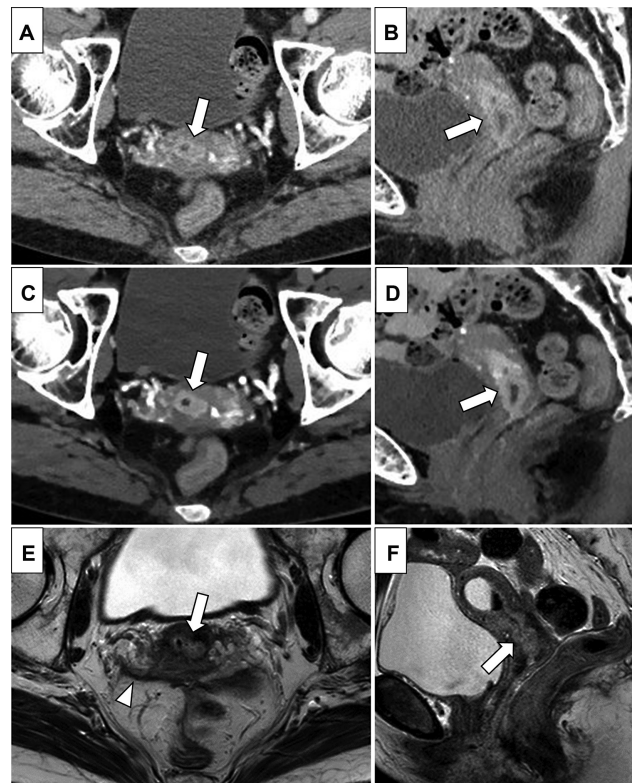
A 73-year-old female patient with cervical cancer (adenocarcinoma), pathologically diagnosed with International Federation of Gynecology and Obstetrics (FIGO) 2018 IB2. (A, B) Conventional computed tomography (C-CT) axial, sagittal images. (C, D) Virtual monoenergetic image (VMI) axial, sagittal images. (E, F) T2-weighted image (T2WI), sagittal images. C-CT shows a tumor with strong enhancement confined to the cervix (A, B; arrows). The contrast is accentuated at VMI (C, D; arrows). On T2WI, the tumor shows high signal intensities (E, F; arrows). On C-CT, one reader could not detect the tumor. On VMI, all readers made the correct diagnosis. On magnetic resonance imaging (MRI), three readers overdiagnosed as extending to the pelvic wall with involvement of the vaginal wall (E; arrowhead, which is considered a combination of vascular and peritoneal thickening).
